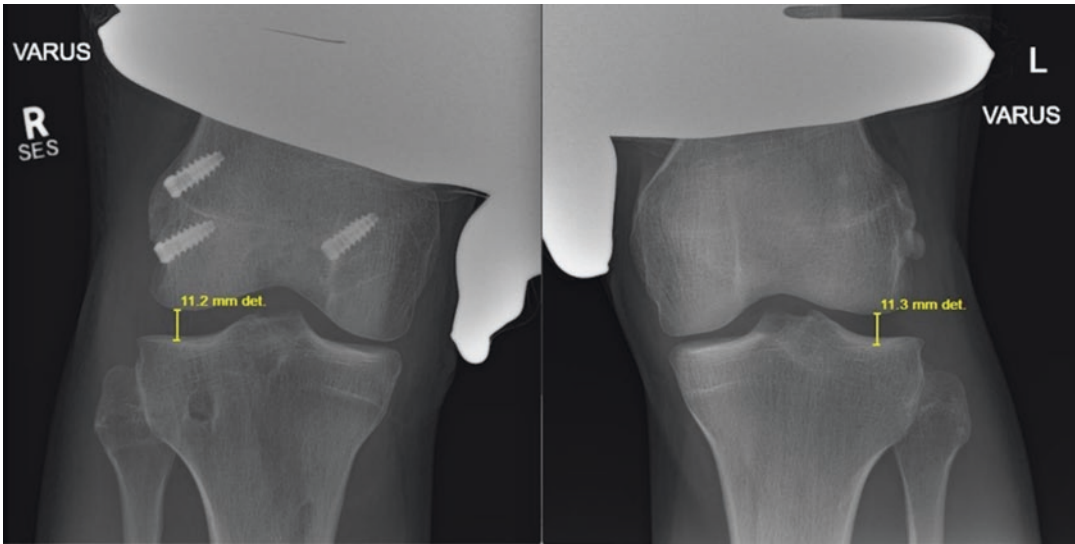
Bilateral varus stress radiographs at 6 months post-op, following a multiligament injury and subsequent posterolateral corner reconstruction (PCLR).
